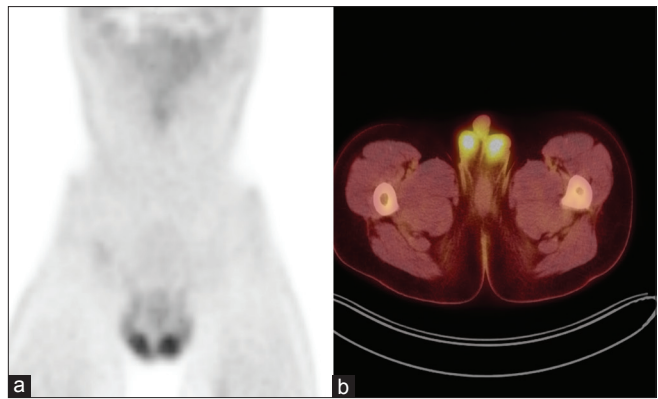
Example of positron emission tomography/computed tomography images in a patient with symmetric testicular uptake of fluoro-2-deoxyglucose, coronal (a) and axial (b)
